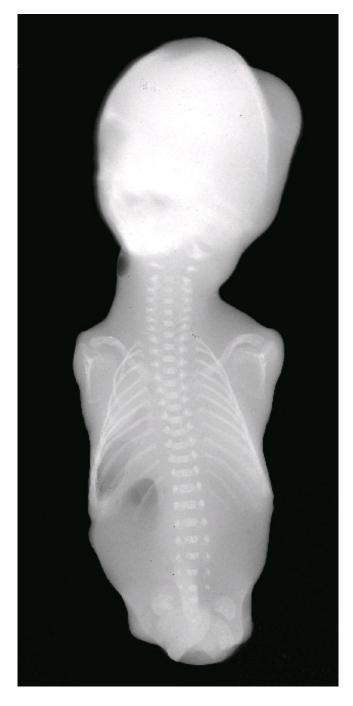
Postmortem radiograph of fetus with tetra-amelia syndrome demonstrating absence of all four limbs (without defects of scapulae and clavicles)
